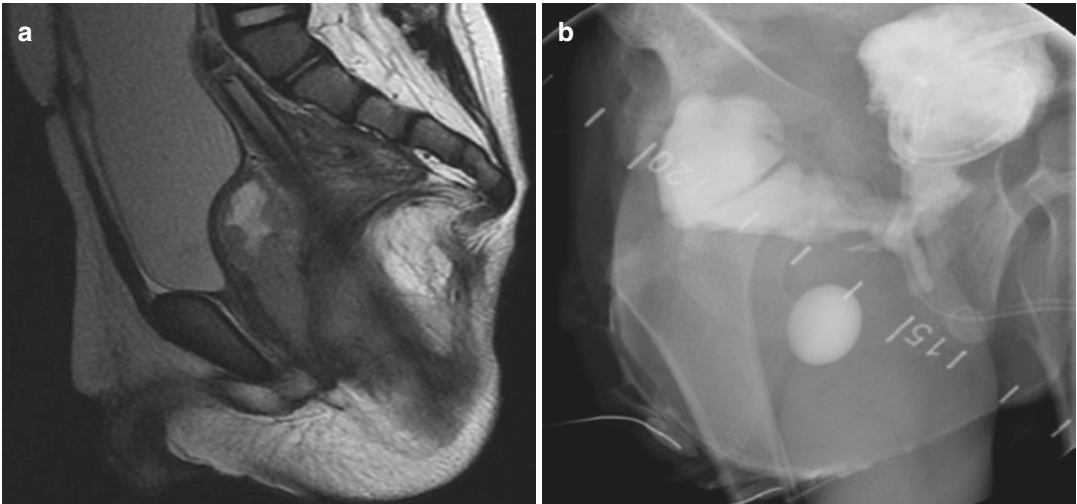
(a) MRI demonstrating large ROOF emanating from the prostate. (b) VCUG demonstrating filling of the ROOF with contrast
